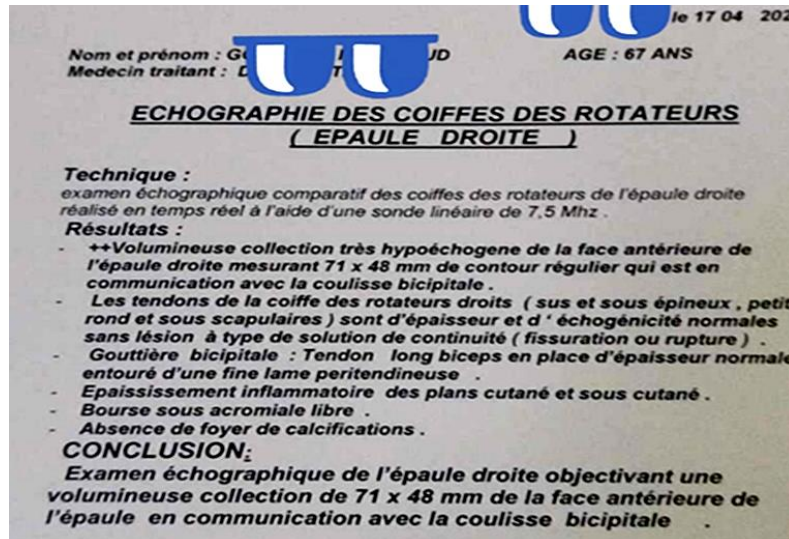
Emergency ultrasound showing extensive soft tissue infection.
